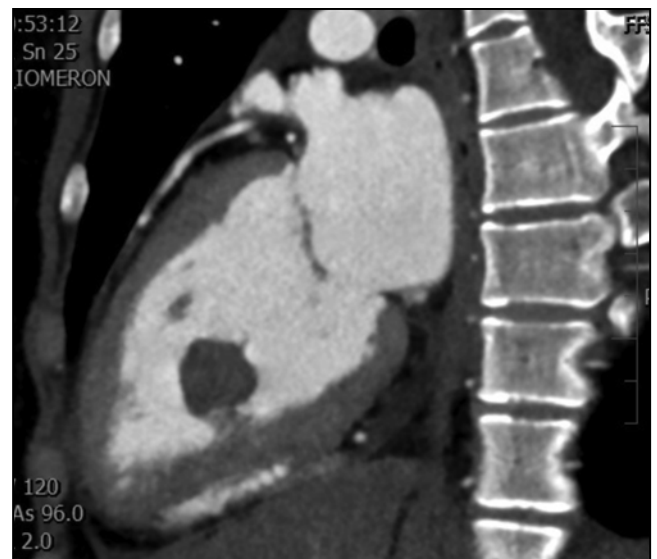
Cardiac CT scan – an expansive tumour in the left
